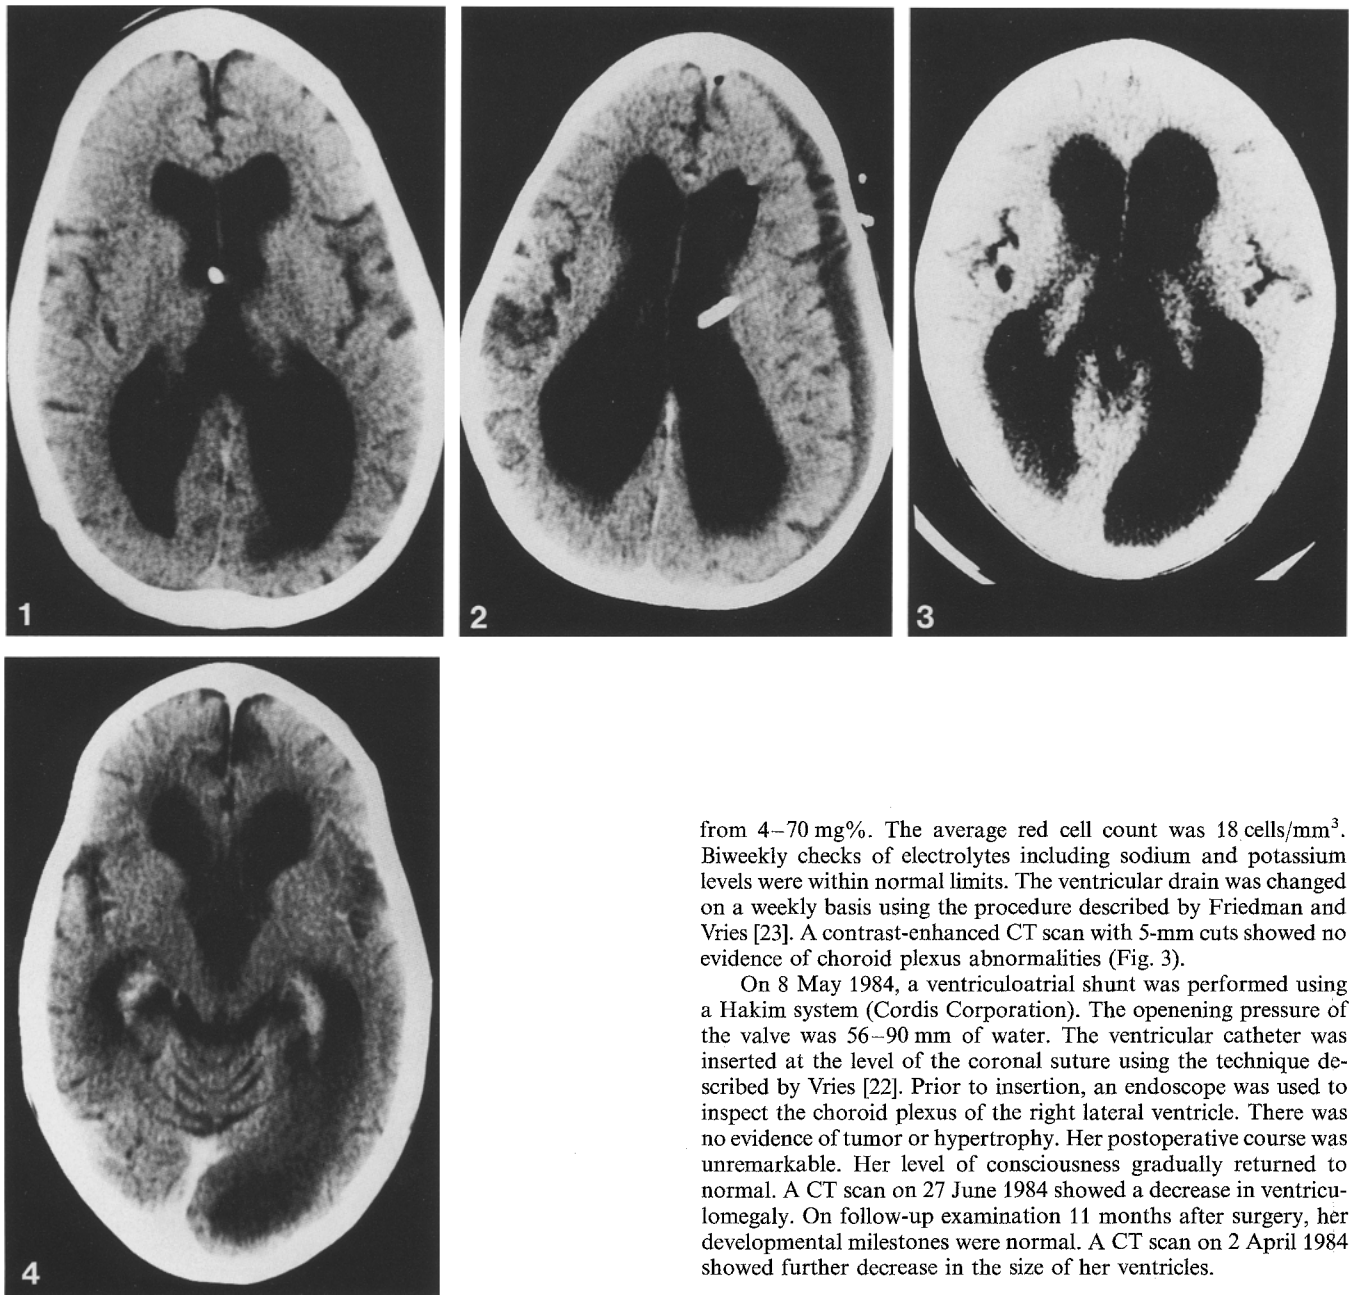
CT scan at 6 months of age demonstrating significant ventriculomegaly
